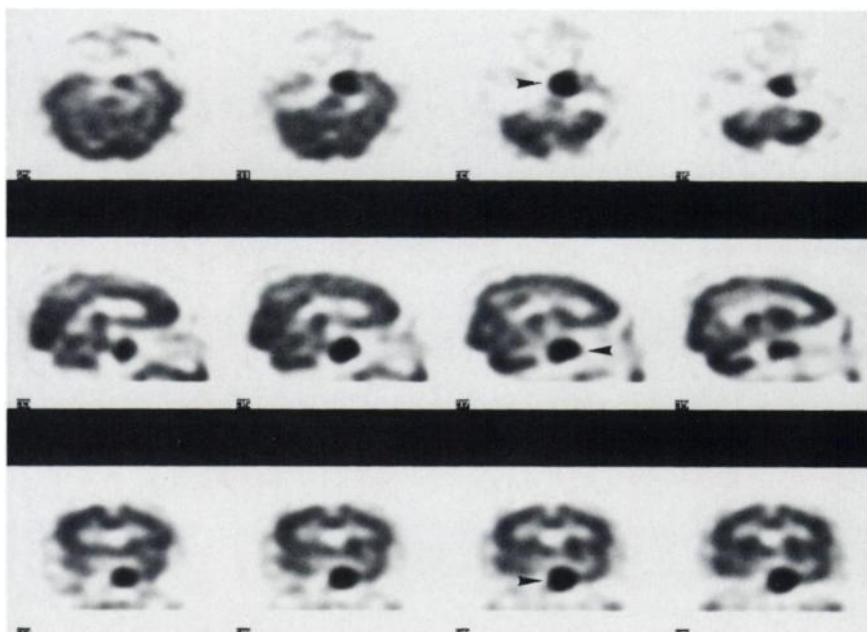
Axial, sagittal and coronal images (upper, middle and lower row, respectively) of ^{99m}Tc -HMPAO brain SPECT shows intensely increased activity (arrows) at the base of the skull.
